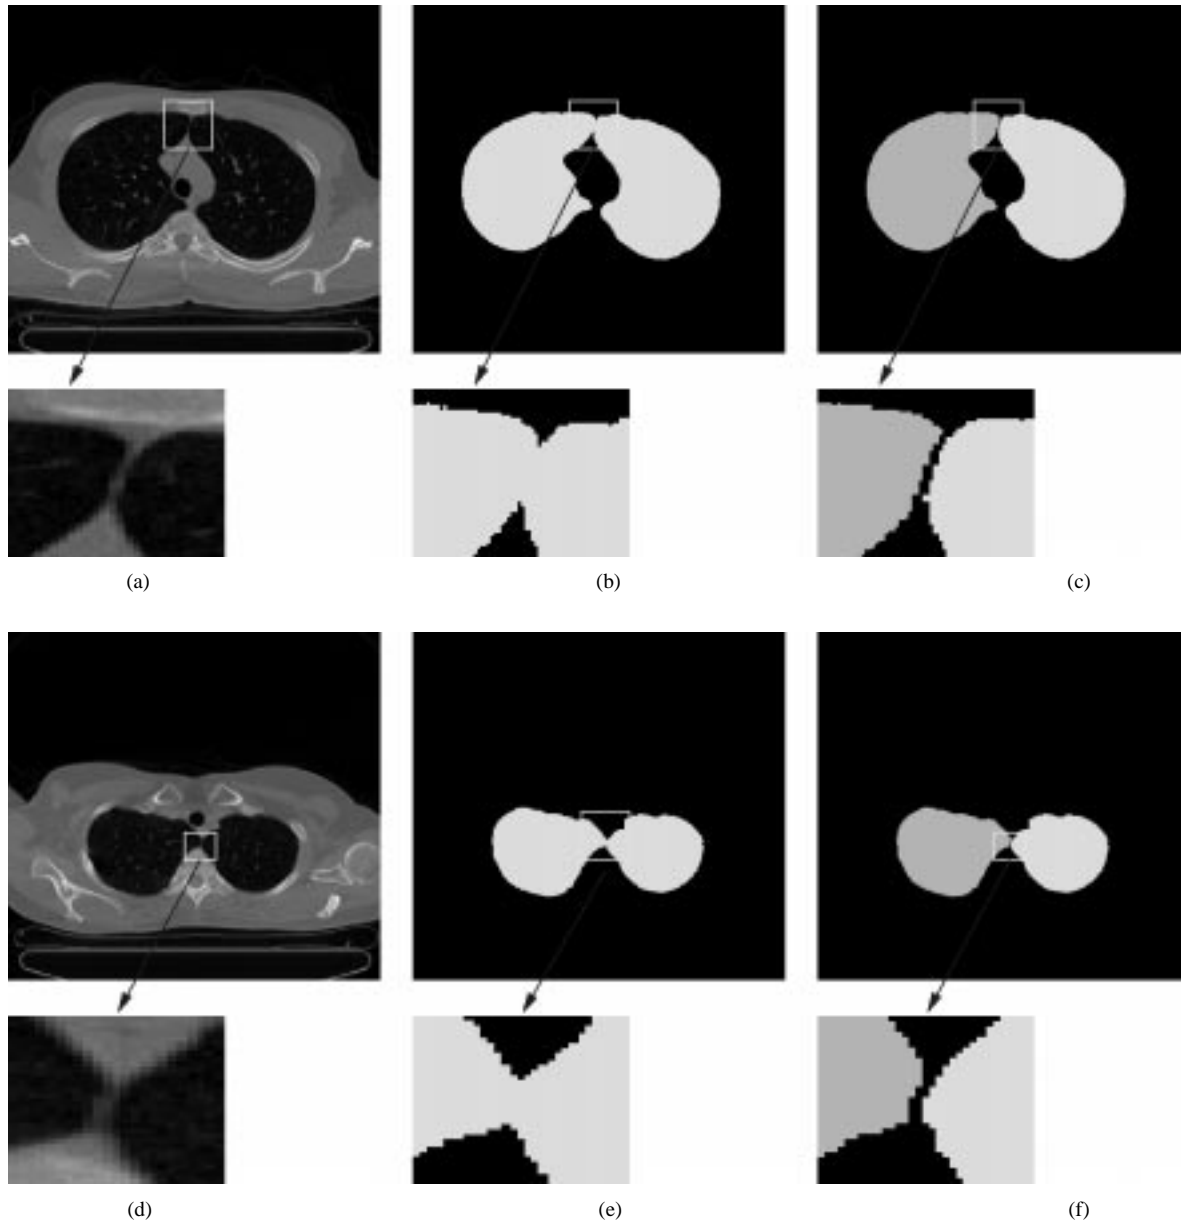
(a), (d) Transverse CT slices from two healthy subjects. (a) Approximately 2.4 cm above carina. (d) Approximately 3.6 cm above carina. (b) and (e) show results after the initial lung segmentation. The left and right lungs are connected. (c) and (f) show results after two lungs are separated.
